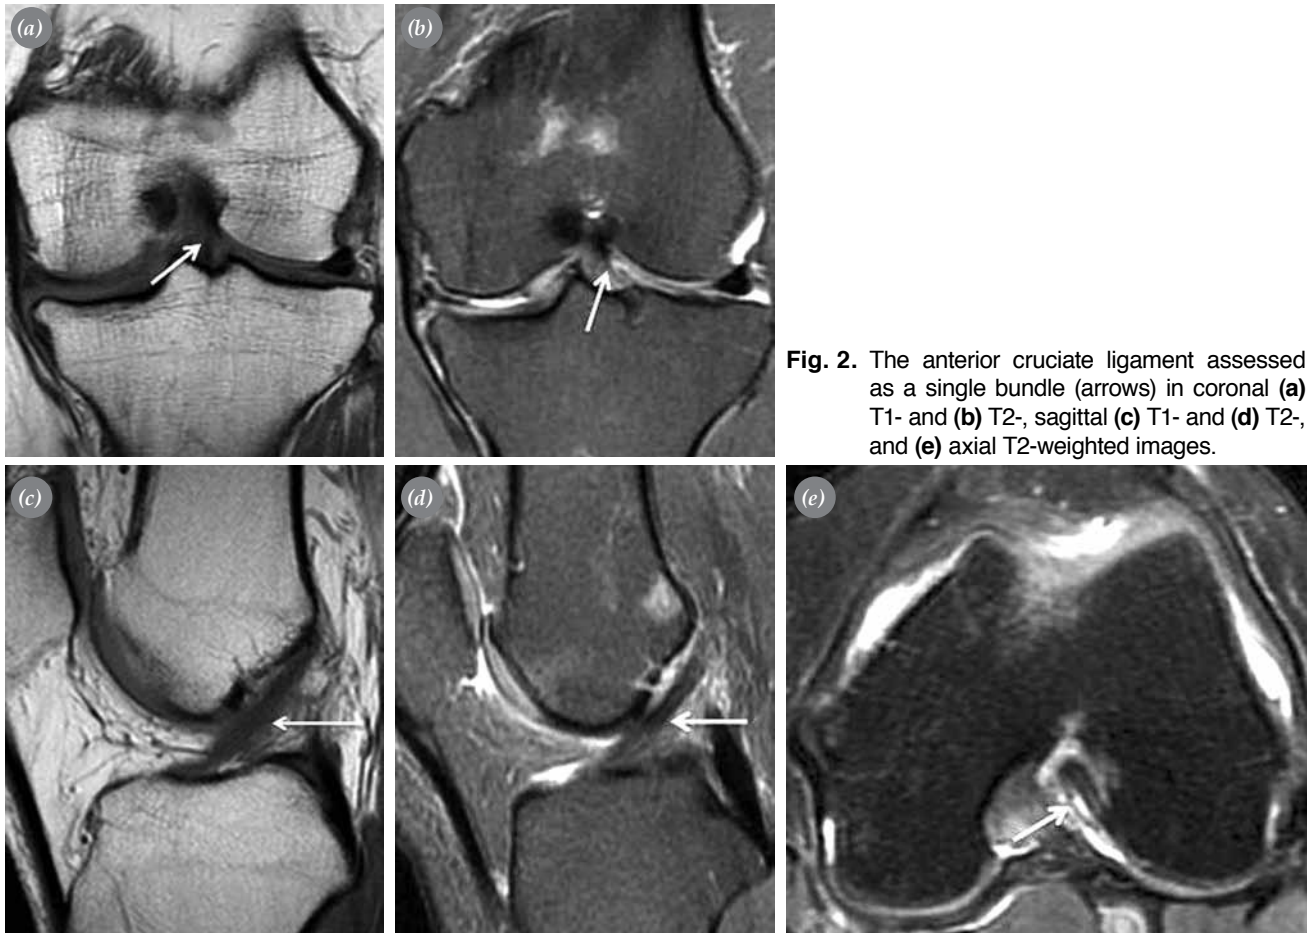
The anterior cruciate ligament assessed as a single bundle (arrows) in coronal (a) T1- and (b) T2-, sagittal (c) T1- and (d) T2-, and (e) axial T2-weighted images.
